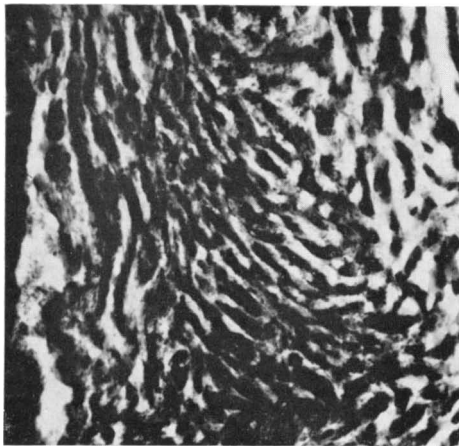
Osteoblastic tumour. Micro-radiograph showing strong mineralisation in tumour bone. Ground section 33 \times .
